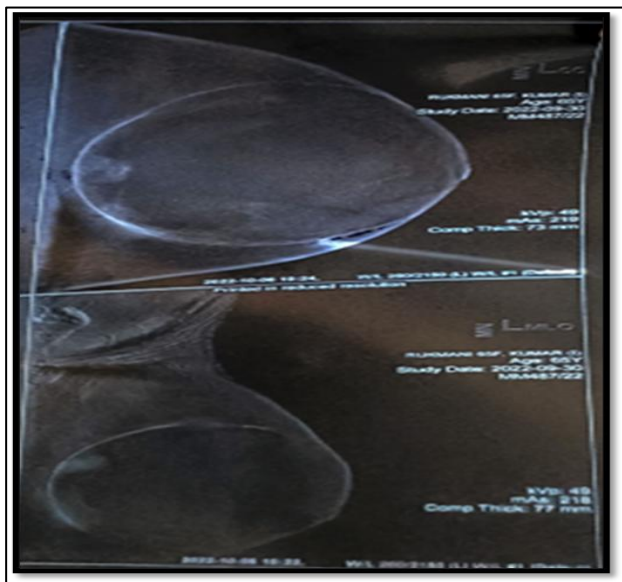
X-ray mammogram.
